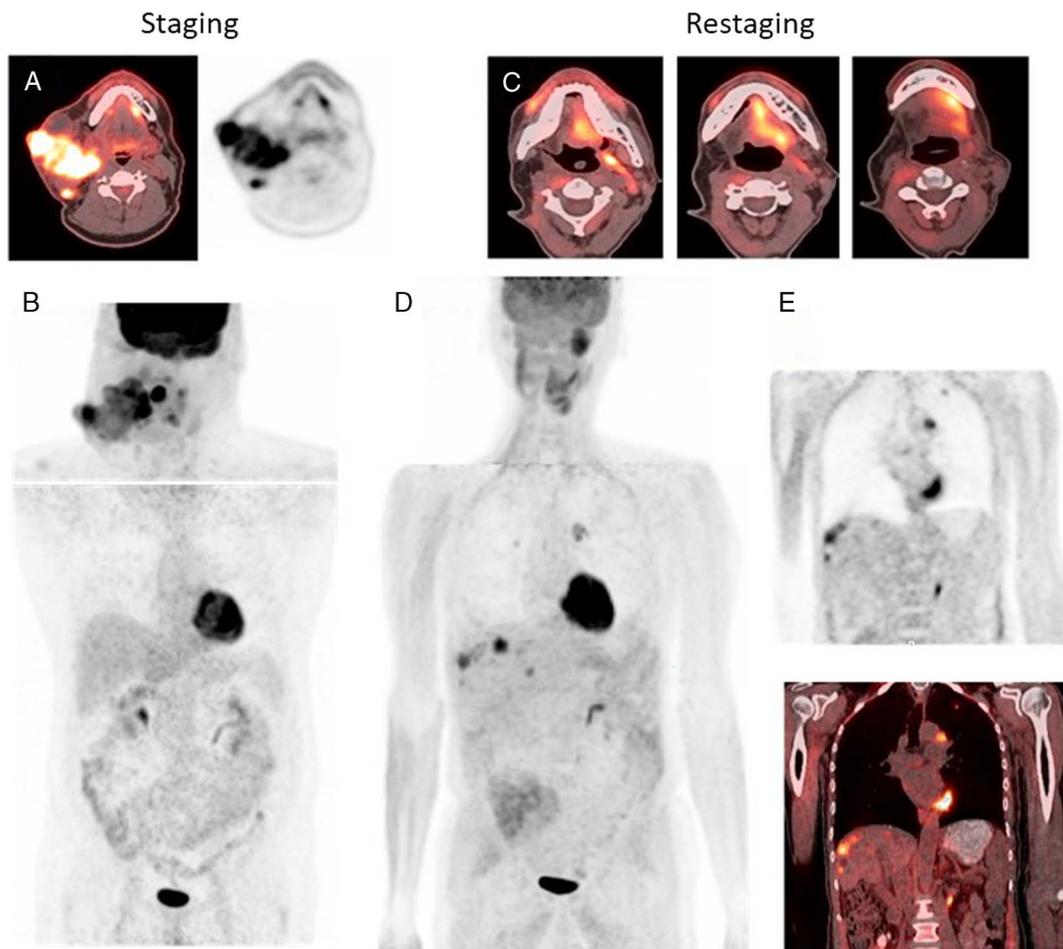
Detection of metastasis. A 59-year-old man who presented T1N3M0 (IVB) HPV-negative poorly differentiated squamous cell carcinoma of the right tonsil, treated with CRT and neck dissection. Liver metastases, pulmonary, mediastinal, and right hilar metastases detected after 9 months from the end of therapy. Axial PET/CT fused and PET images (A) showed intensely FDG uptake in primary tumor site. MIP images (B) showed primary tumor without distant metastasis 9 months after finishing CRT and neck dissection, complete therapy response at primary tumor site in FDG PET/CT images (C). MIP images (D) showed metabolically active metastatic disease in the liver, left lung, and mediastinal, right hilar lymph nodes. Coronal PET/CT fused and PET images (E) showed liver, left lung, mediastinal lymph nodes.
